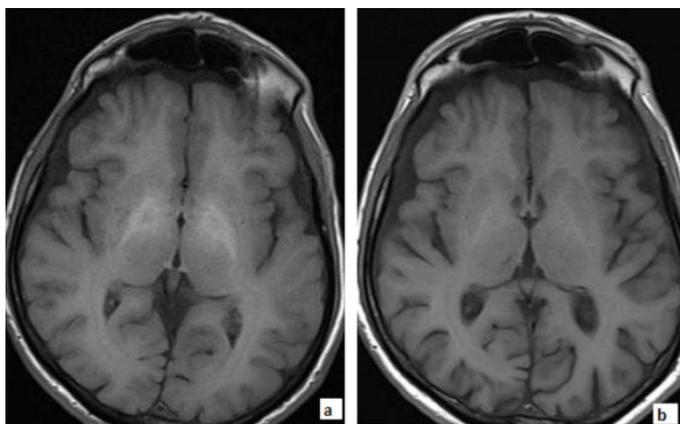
Hyperintense foci compatible with manganese accumulation at the basal ganglia (Figure 1a) that can be seen on the axial T1-weighted brain MR image of 64-year-old male patient who underwent liver transplantation due to chronic hepatitis B infection seems to have disappeared on the post-transplant brain MRI (Figure 1b).
